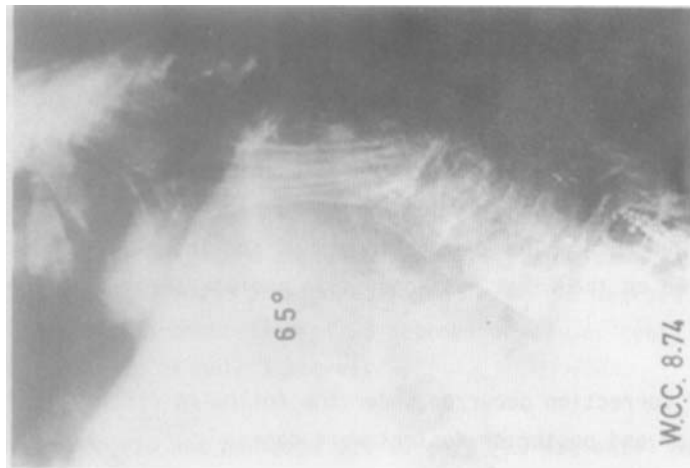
b. Lateral radiograph three years and five months after surgery. No loss of correction has occurred.
